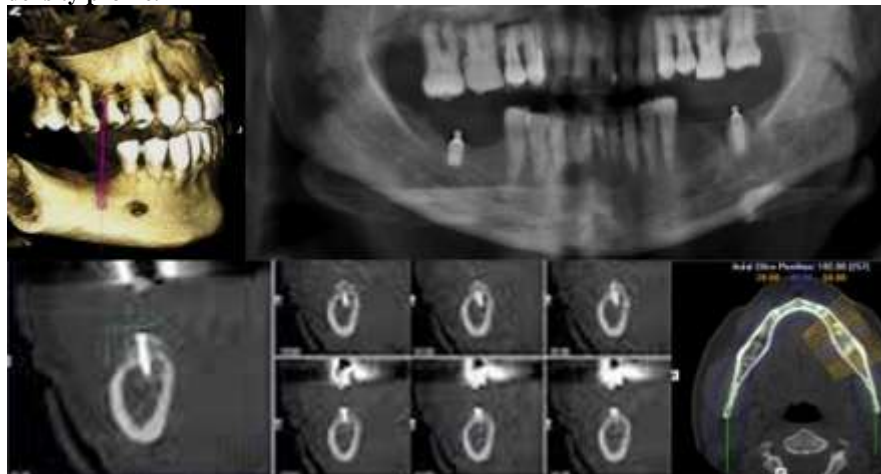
Cone beam computed tomography (CBCT) showing the reconstructed three-dimensional model of one of the patients, the panoramic view, and the para-axial cuts.
